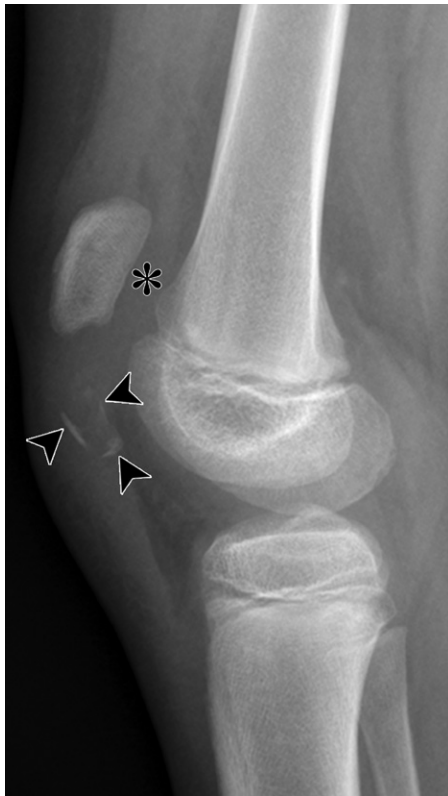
Patellar sleeve fracture in an 11-year-old boy. Lateral radiograph shows fragments of bone (arrowheads) arising from the inferior patella associated with soft-tissue thickening of the anterior soft tissues and an effusion (*) in the joint. The patella is superiorly elevated with a patella alta deformity. (Courtesy of Jonathan Zember, MD, Children's National Medical Center, Washington, DC.)
